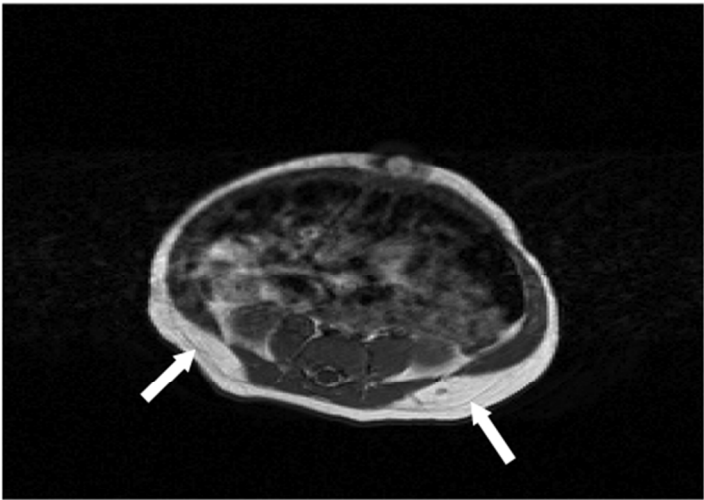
T1 weighted axial magnetic resonance image (abdominal level) demonstrating the deep and superficial subcutaneous adipose tissue depots. A clear fascial plane is noted between the superficial and deep subcutaneous layers (arrows).
